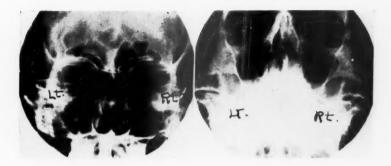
X-ray pictures demonstrating obstructive aerosinusitis of the left frontal and maxillary sinuses (Case 3).
